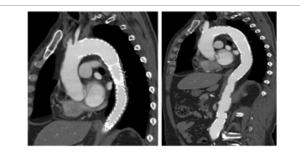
CT (postoperative at 6 months) The postoperative CT showed that the false lumen had disappeared completely.
